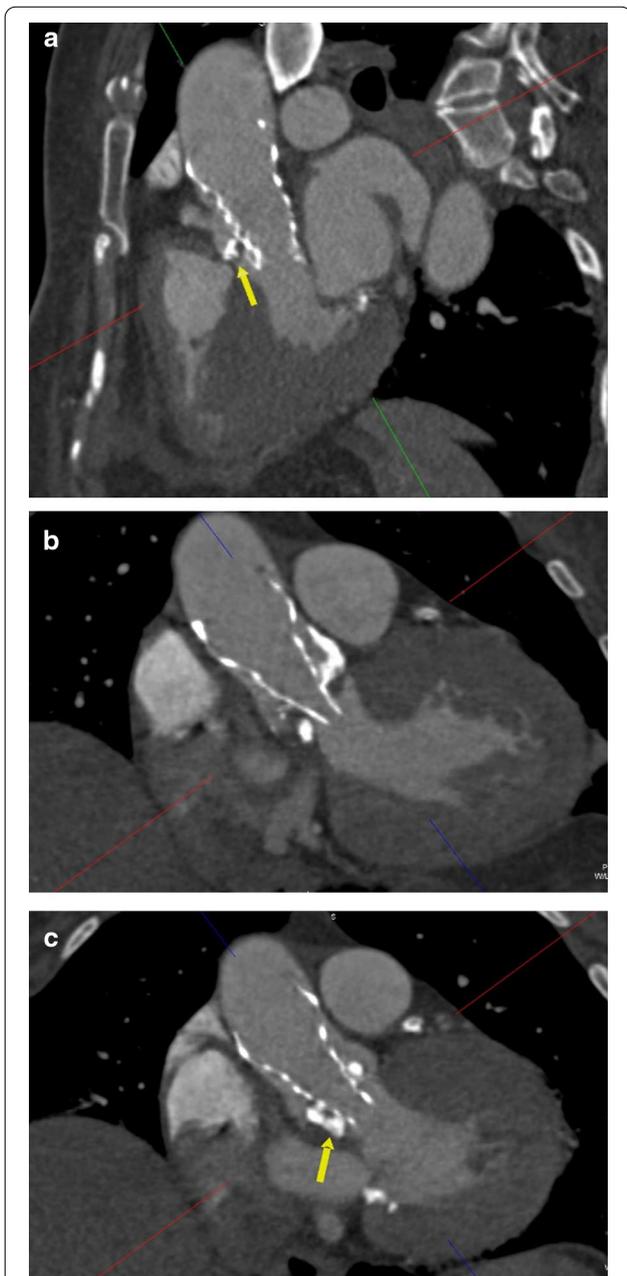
CT aortography, coronal plane, for patient presented by post-procedure complications showing aortic valve prosthesis not well deployed due to extensive aortic root calcifications (arrows)
